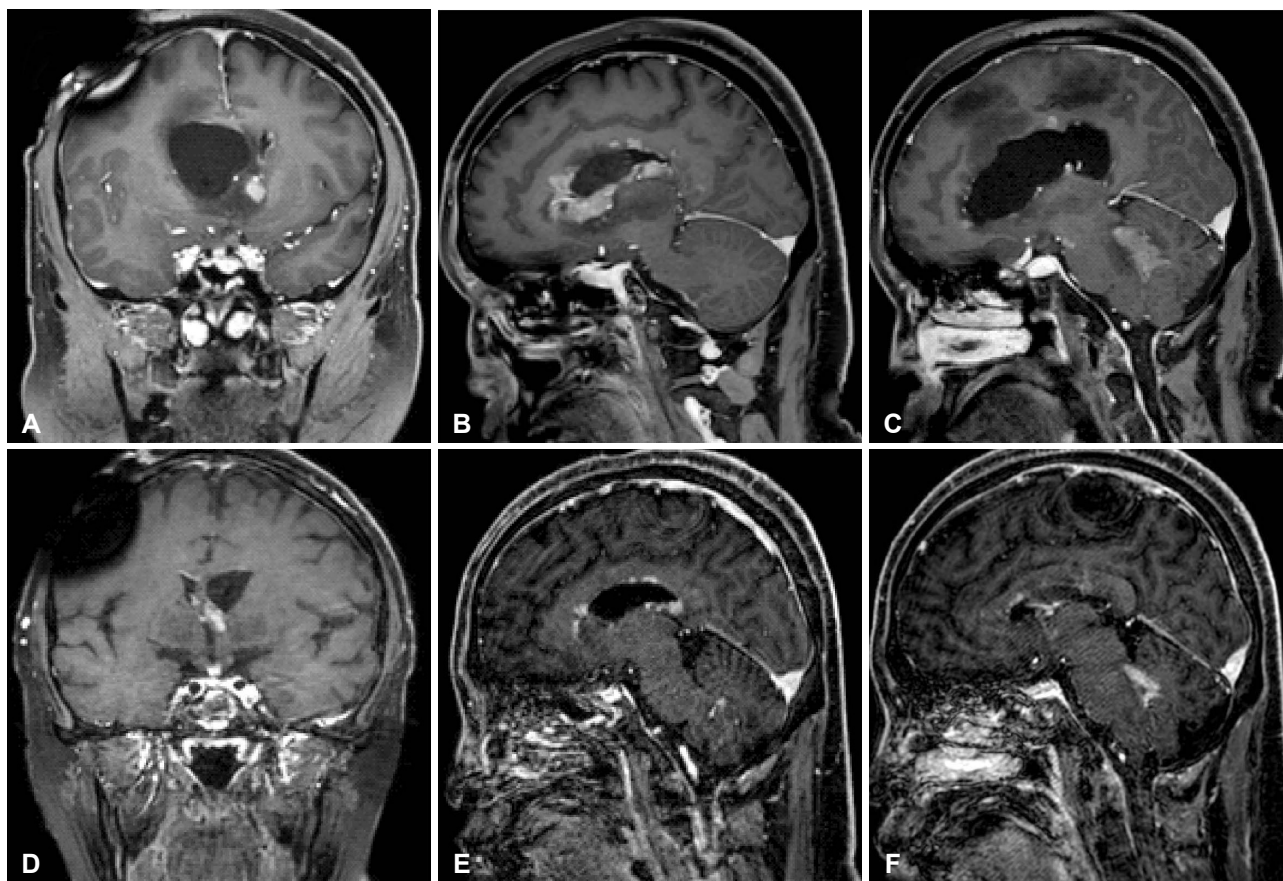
Contrast-enhanced T1-weighted MRI findings following treatment interventions. MRI performed after ventriculoperitoneal shunt placement and intravenous antibiotic therapy demonstrated persistent enhancing lesions. A: Coronal view showing an enhancing lesion in the sellar and suprasellar region. B: Sagittal view demonstrating enhancement along the ventricular lining. C: Sagittal view showing an enhancing lesion in the cerebellum. D-F: Follow-up MRI after whole-brain radiotherapy revealed a marked reduction in overall disease burden.
